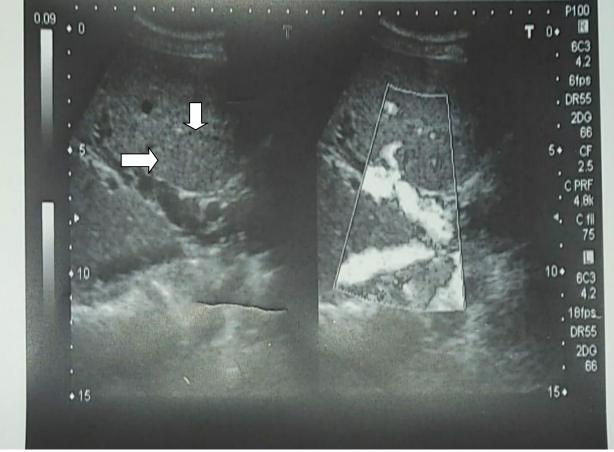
Cavernous transformation of portal vein as shown by Duplex Doppler study (arrow heads)
